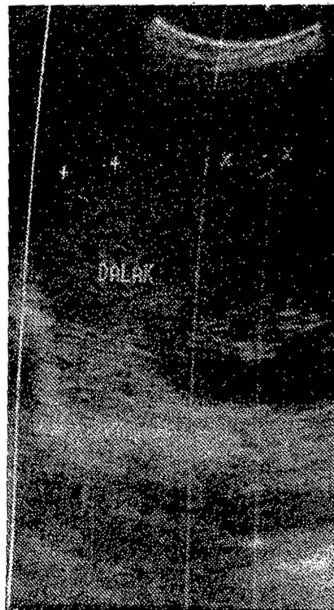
Ultrasonography showing 14, 19 and 13 mm hydatid cysts in the spleen.
